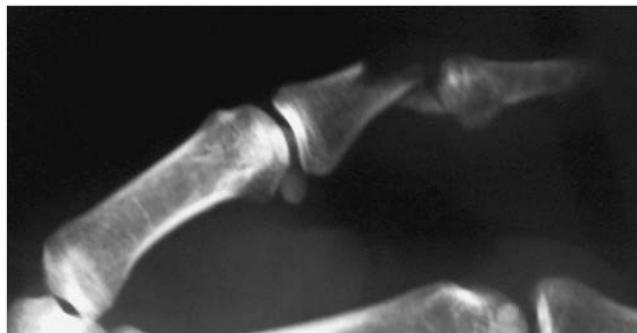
Radiograph taken at first presentation showing the bone loss.
